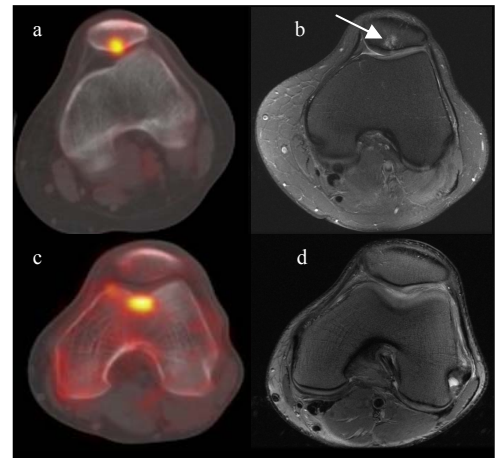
^{18}F NaF PET/CT image (a) and corresponding high-resolution MR image (b). Increased tracer uptake (yellow/red overlay) found on posterior patella in PET/CT image indicating increased bone activity. Tracer uptake corresponds to bone marrow edema (arrow) detected with MRI. ^{18}F NaF PET/CT image (c) with increased tracer uptake in trochlea. Corresponding MR image (d) showing no bone or cartilage defects.
